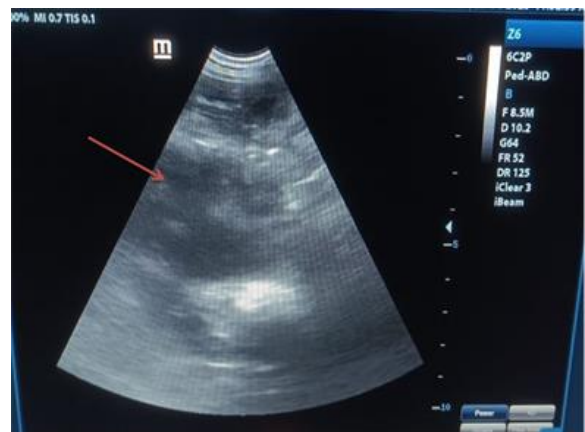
Ultrasonography of uterus reveals anechoic fluid with echogenic particles.
